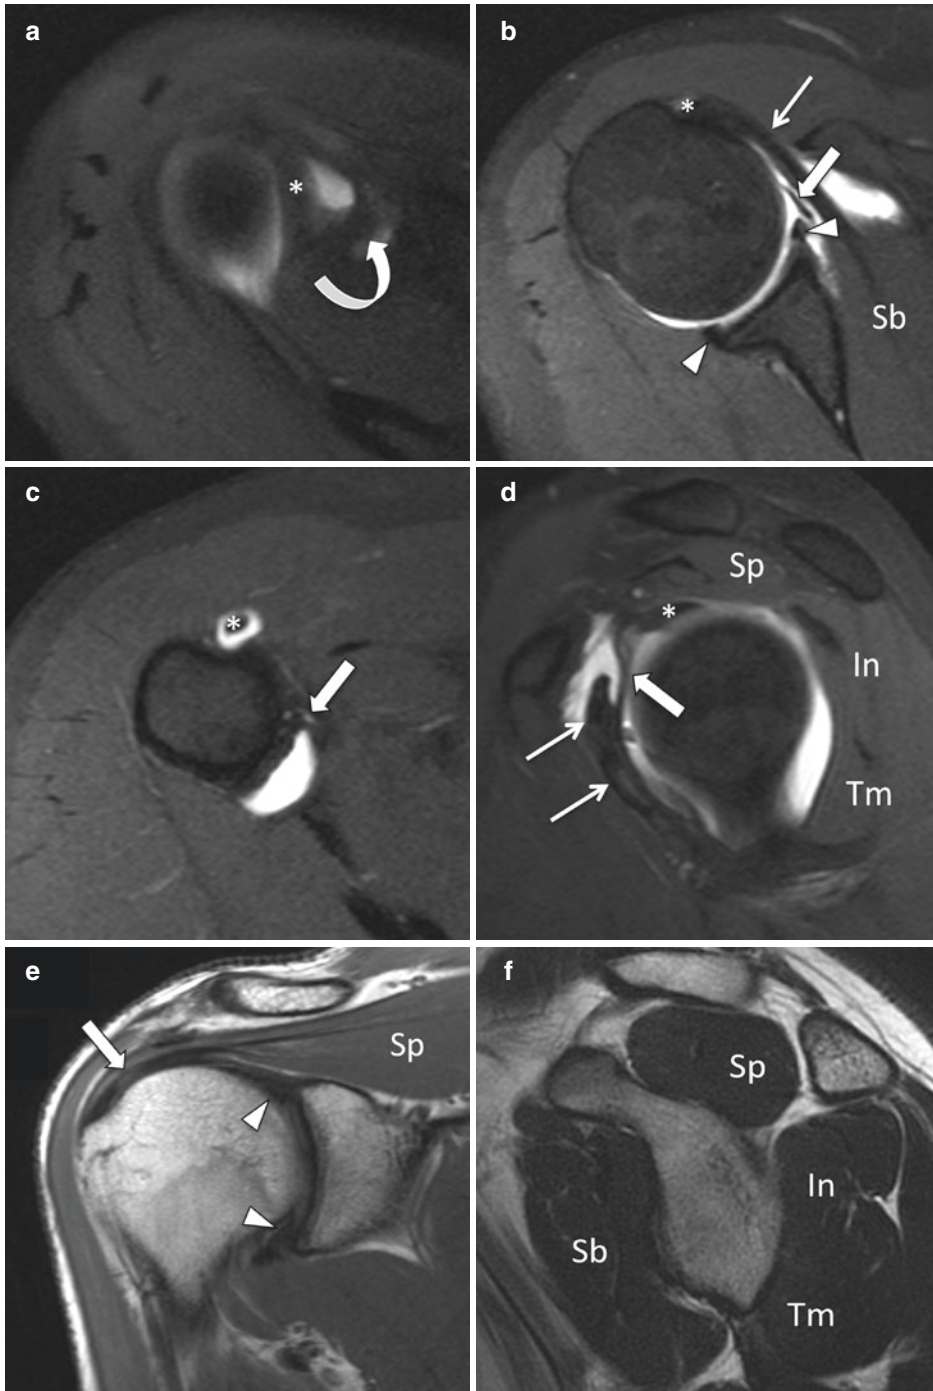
Normal anatomy. Axial (a–c), sagittal (d), fat-saturated MR arthrographic, coronal nonfat-saturated T1-weighted (e), and sagittal nonfat-saturated T2-weighted MR images (f) demonstrating the normal MR appearance of the glenohumeral joint stabilizers. Long head of the biceps tendon = asterisk; superior glenohumeral ligament = curved arrow; middle glenohumeral
